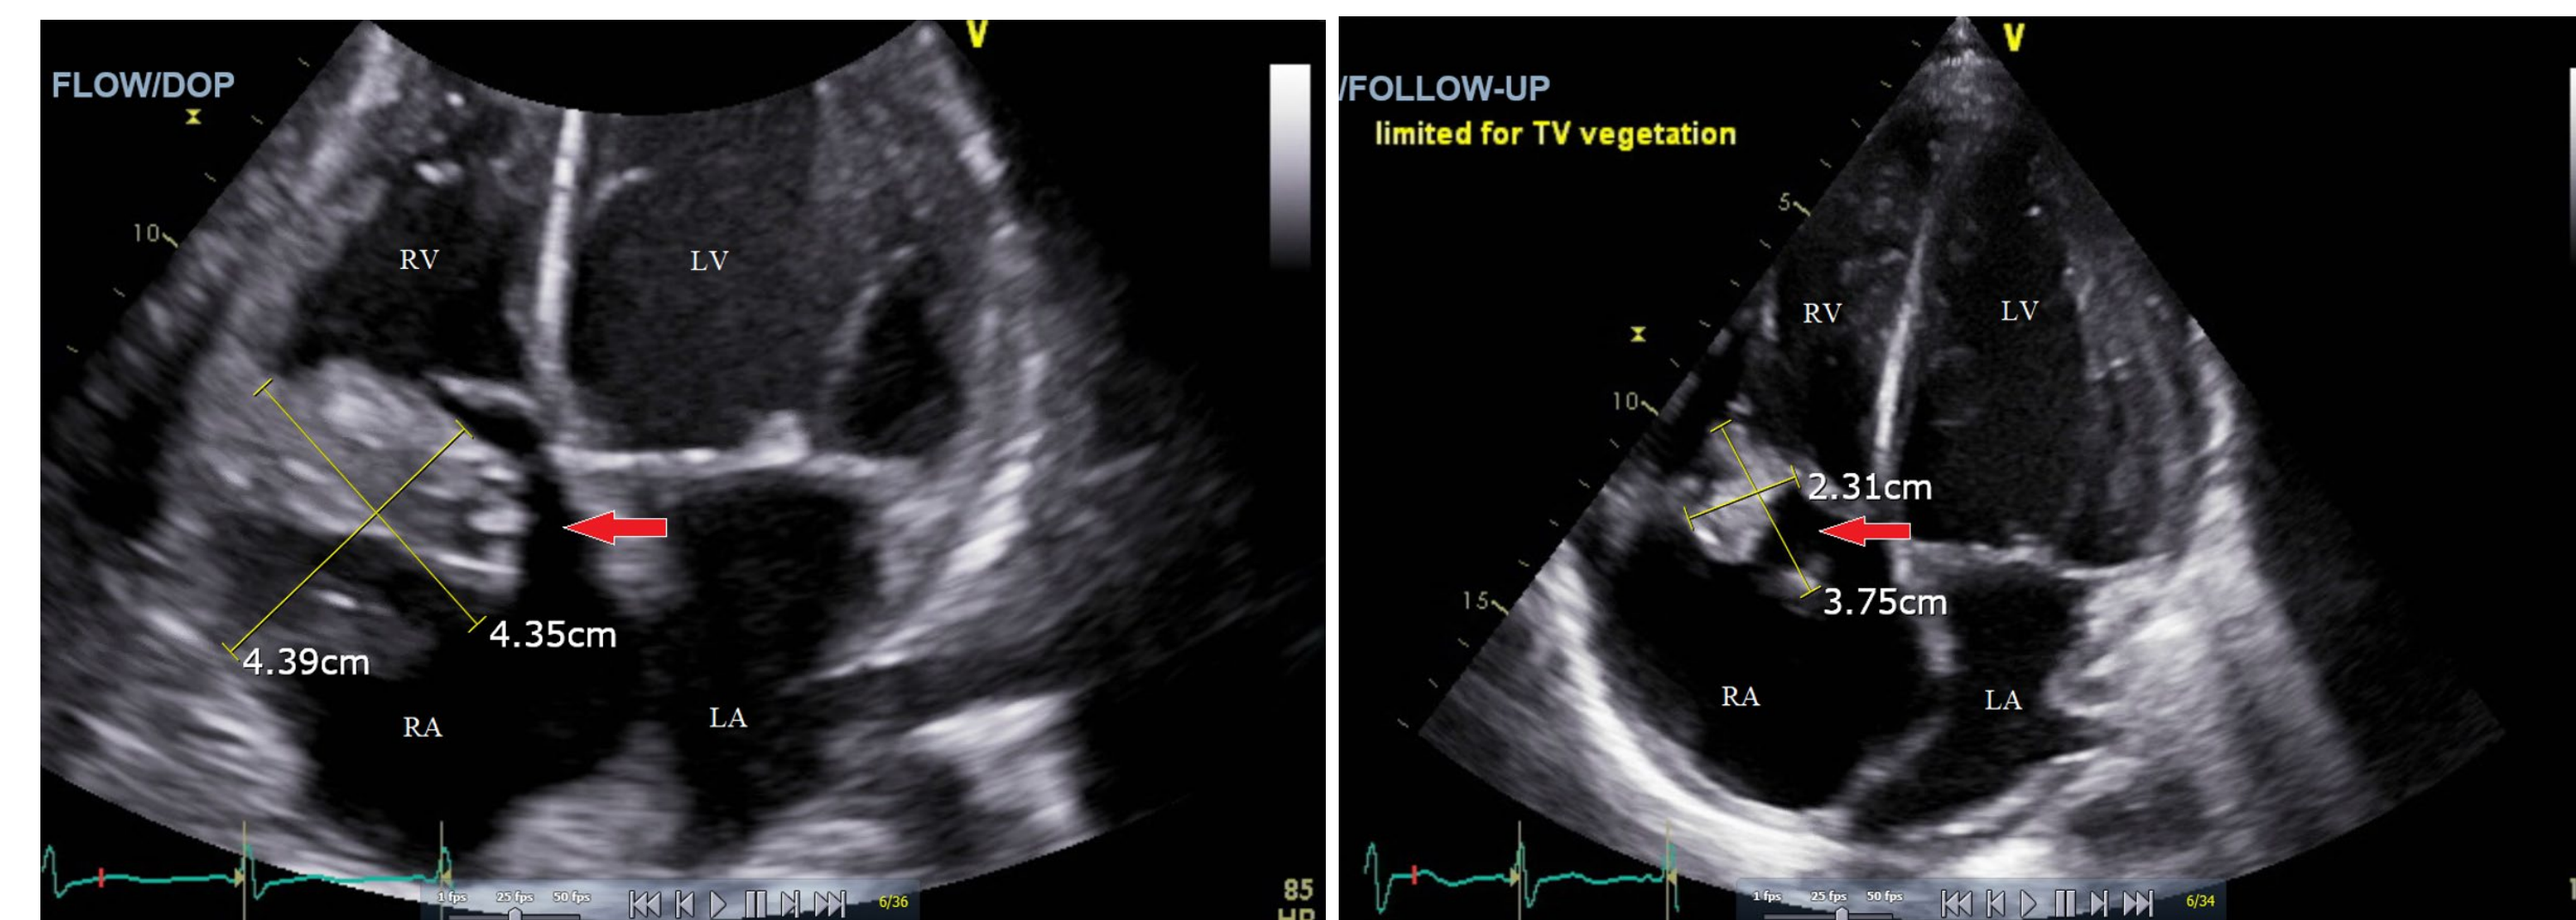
Transthoracic echocardiogram via four chamber view with red arrow pointing to vegetation before (left) and after (right) AngioVac® procedure. RA = right atrium, RV = right ventricle, LA = left atrium, LV = left ventricle.
